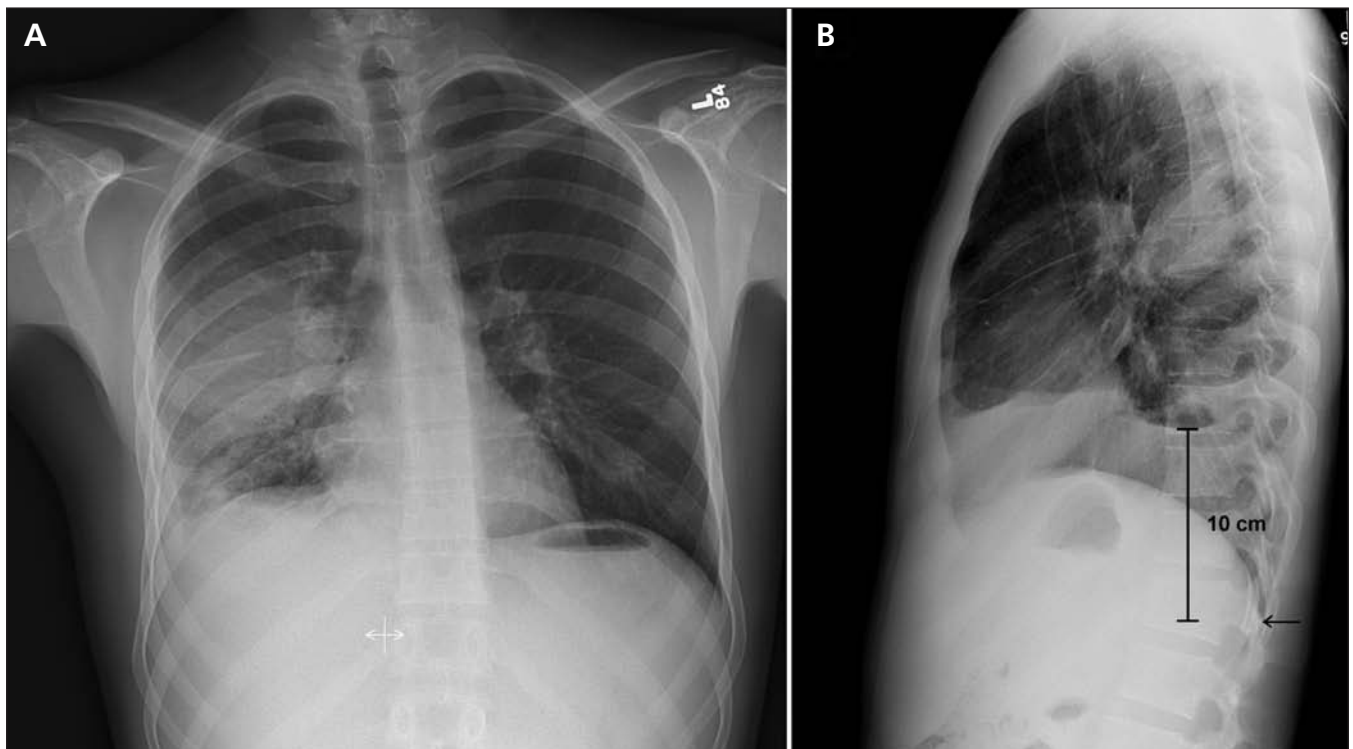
Chest radiographs showing a parapneumonic effusion requiring diagnostic thoracentesis. (A) Right lower lobe consolidation and a parapneumonic effusion (posterior anterior view). (B) Pleural effusion measuring 10 cm from the inferior costal sulcus (arrow) to the bottom of the meniscus of the effusion (lateral upright view).
